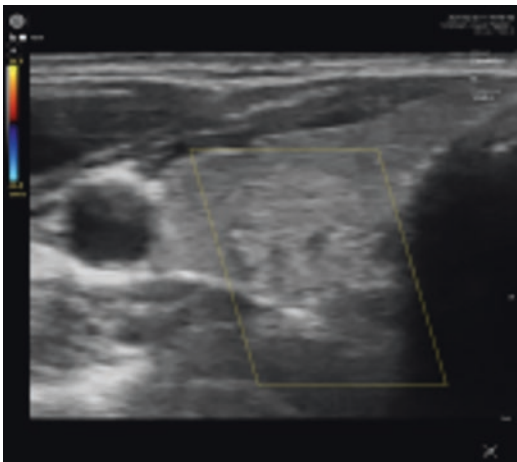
This is an ultrasound image of a normal carotid artery (black) and thyroid gland (gray) in the box
